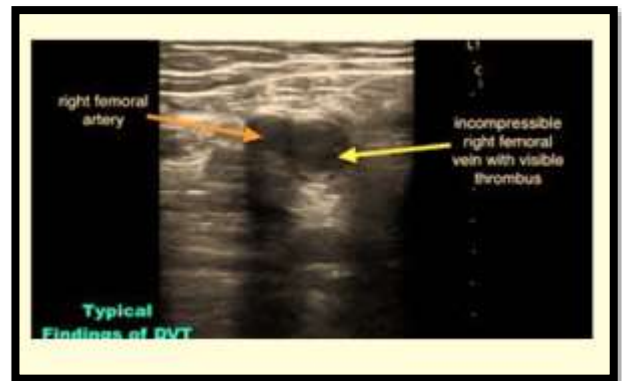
DOPPLER STUDY OF DVT IN RIGHT FEMORAL VEIN
